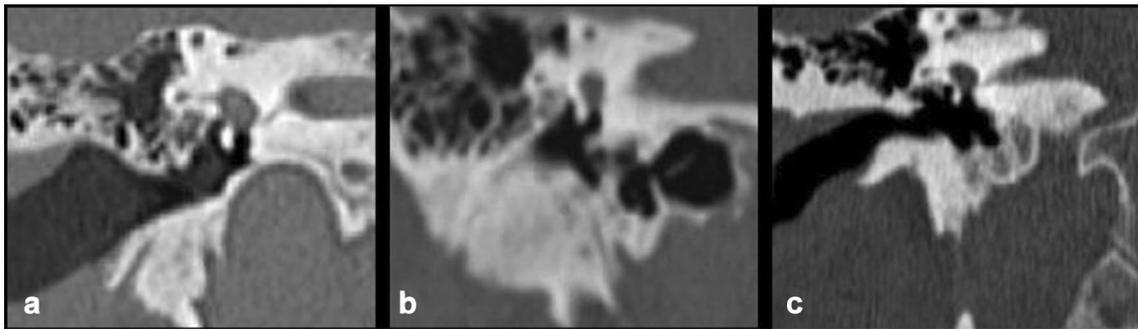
Coronal CT scan reconstructions: a “cylindrical-type” RWN, b “j-type” RWN, c “truncated cone-type” RWN
